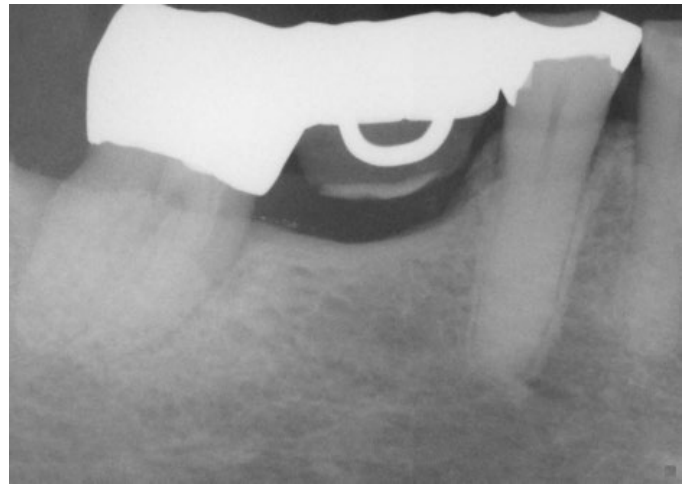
(B) Following LANAP procedures, this post-op X-ray shows a significant amount of bone growth.
